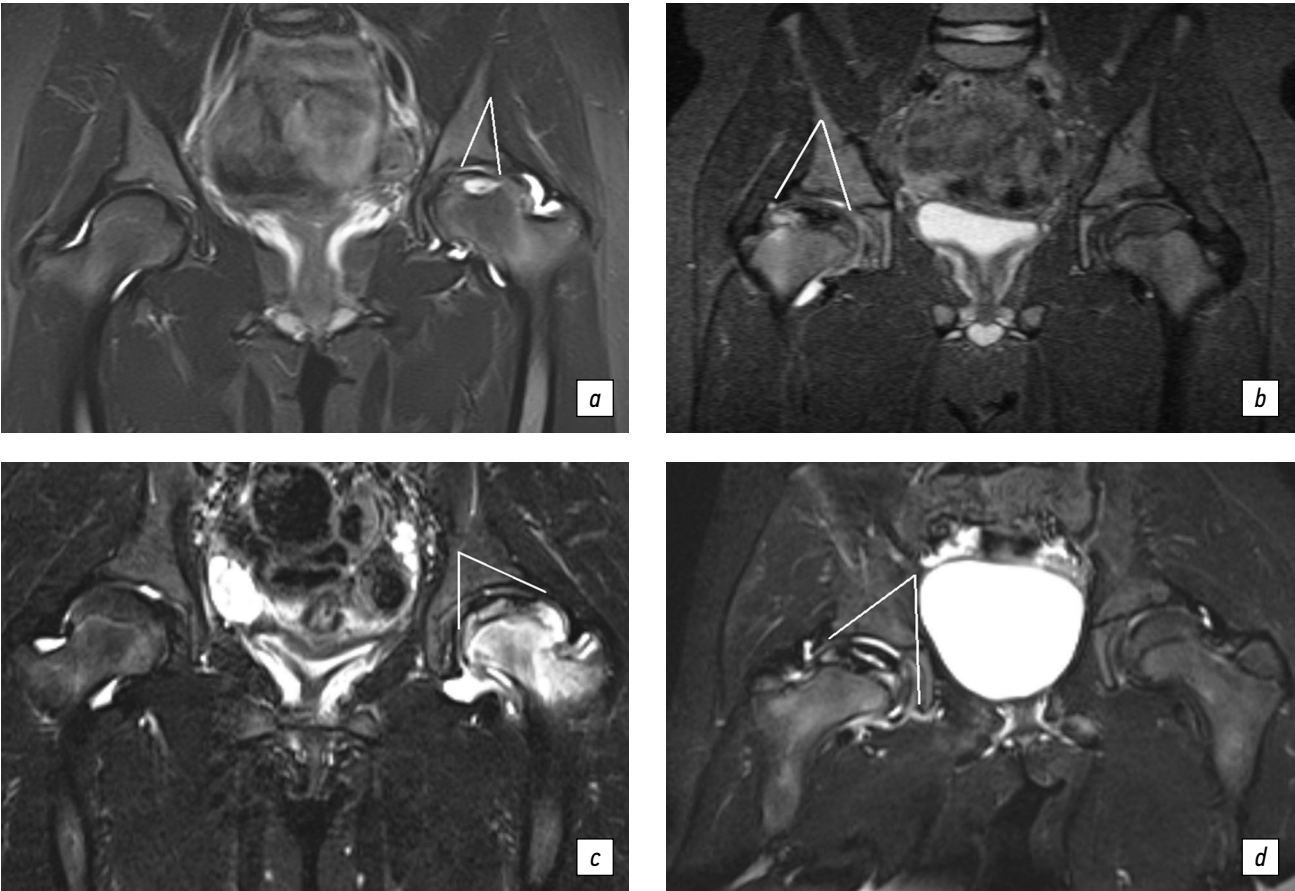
Magnetic resonance imaging: signs of varying severity of femoral head lesions in children with the Legg–Calvé–Perthes disease. STIR mode images show (a) necrotic lesion and trabecular edema occupying $\leq 33\%$ of the epiphysis, (b) necrotic lesion and edema occupying 34%–66% of the epiphysis, (c, d) necrotic lesion and edema occupying 67%–100% of the epiphysis
